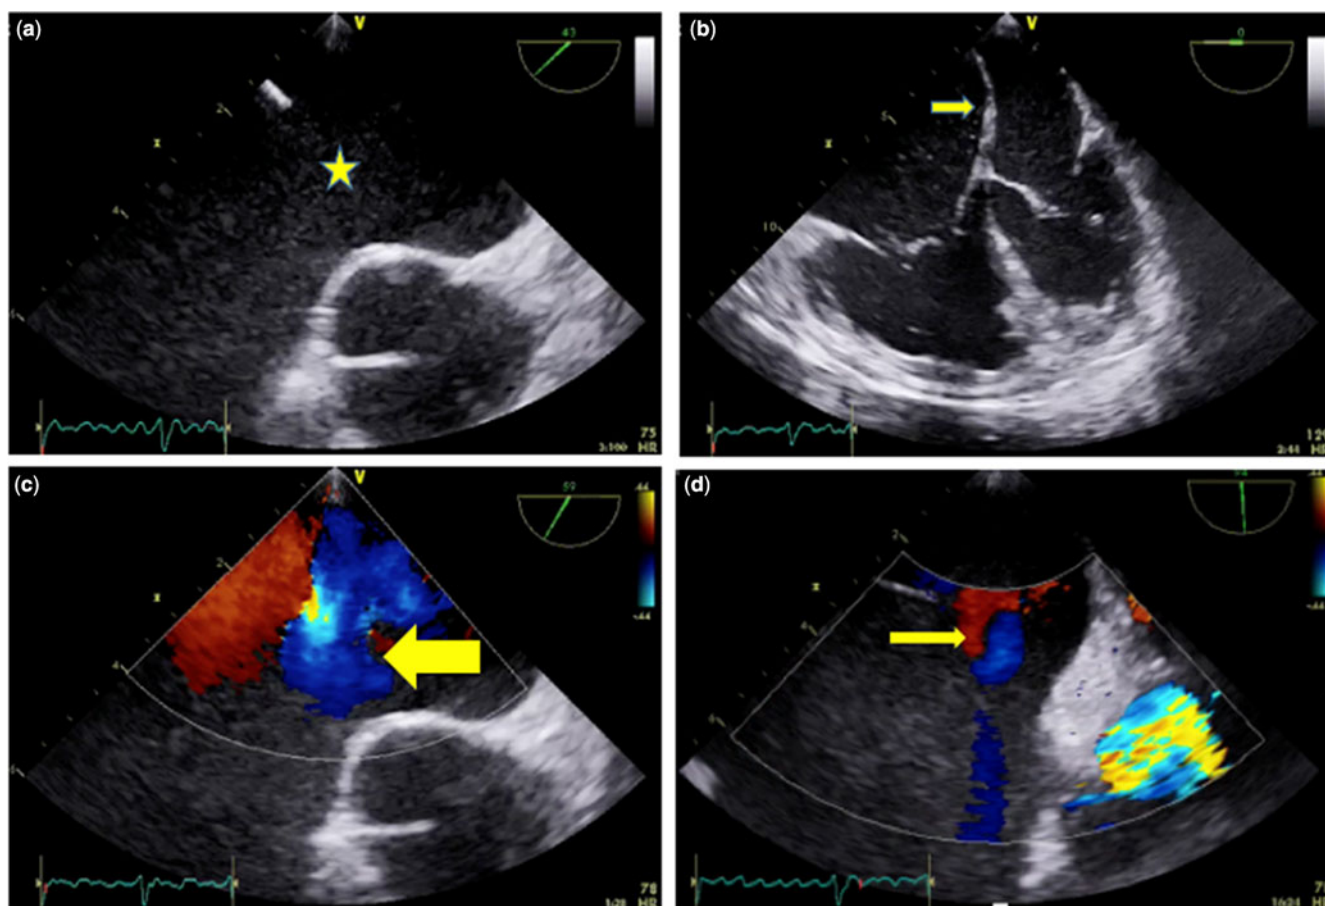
Transoesophageal echocardiogram at first presentation showing a single secundum atrial septal defect (23 mm, stair) with absence of aortic rim. (a) Four-chamber view showing dilated right atrium (RA) and right ventricle (RV). Leftward bowing of the interatrium septum, suggestive of increased RA pressures. (b) Colour flow mapping showing significant left-to-right shunt (arrow) (c) and small right-to-left shunt (arrow) (d).
